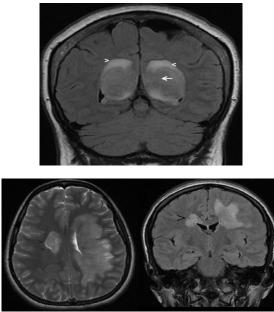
47 years-old-man, signs of coma. Large hyperintense T2 and FLAIR lesion involving the left periventricular white matter and corpus callosum. Note the additional periventricular right lesion (arrowheads).
